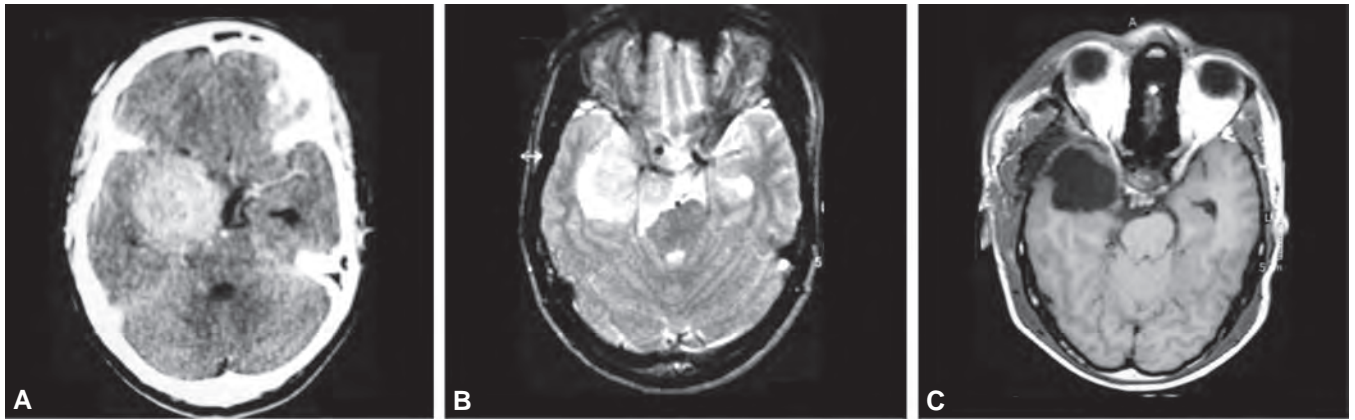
to C: (A) Axial post-contrast CT view shows a right clinoidal meningioma. (B) CT bone algorithm shows hypertrophy of the lesser wing and anterior clinoid. (C) Post-operative axial T1-weighted image shows complete excision of the tumour. A contused right temporal lobe is noted
